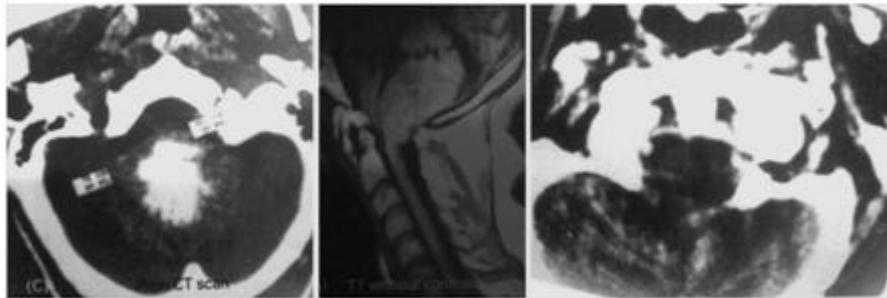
preoperative CT scan and MRI showing huge posterior foramen magnum meningioma. Postoperative CT scan after total excision.
